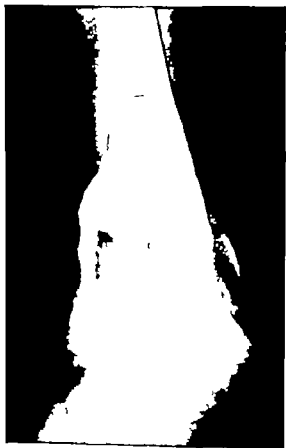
a* (above) and *b* (above right) Anteroposterior and lateral views of benign giant cell tumor of the lower end of the femur. It was treated by insertion of radium following curettage. *c* (right) The same lesion 2 years after treatment. Two years after this roentgenogram was taken the leg was amputated for grade 3 fibrosarcoma which had completely replaced the original benign tumor.
